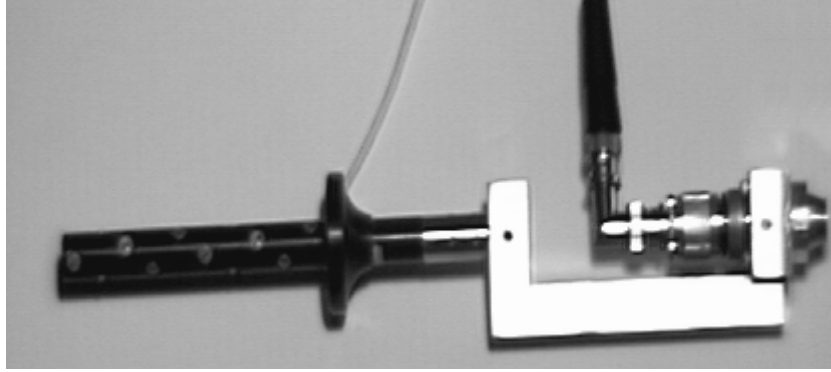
Ultrasound acquisition device
